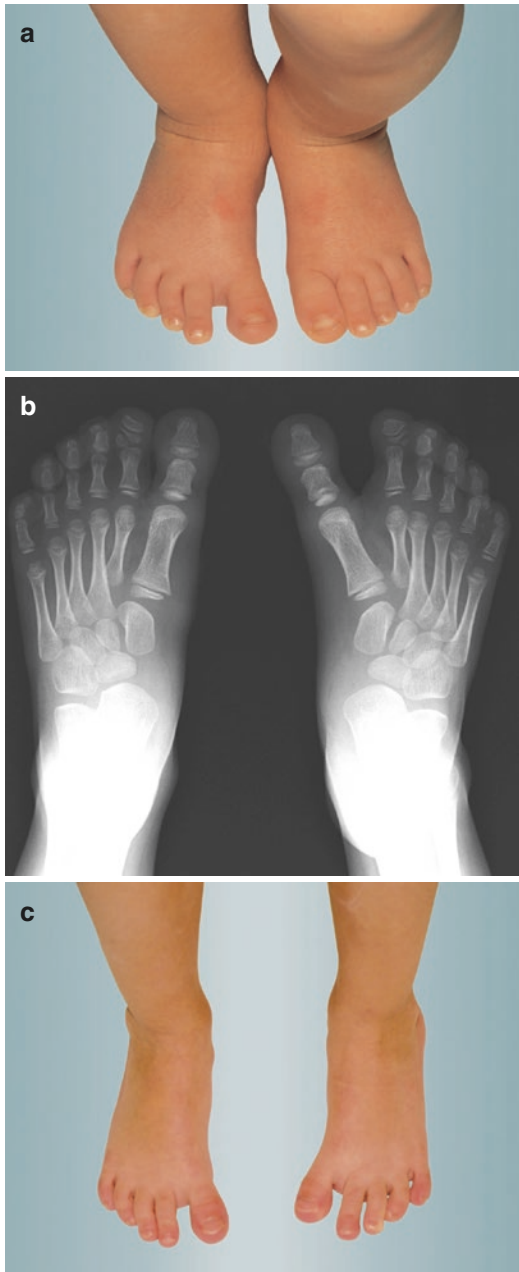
(a) A right sided rigid metatarsus primus varus. The first metatarsal together with the big toe is adducted with regard to the rest of the foot. The space between the big toe and the second toe is conspicuous. (b) Anteroposterior X-ray of the feet. In a metatarsus primus varus the intra-metatarsal angle between the first and second metatarsal is greater than 10° . (c) Bilateral flexible metatarsus primus varus. On weight bearing the big toes are medially displaced. The big toes join the rest of the toes when the feet are non weight bearing. These are often called “searching toes”
